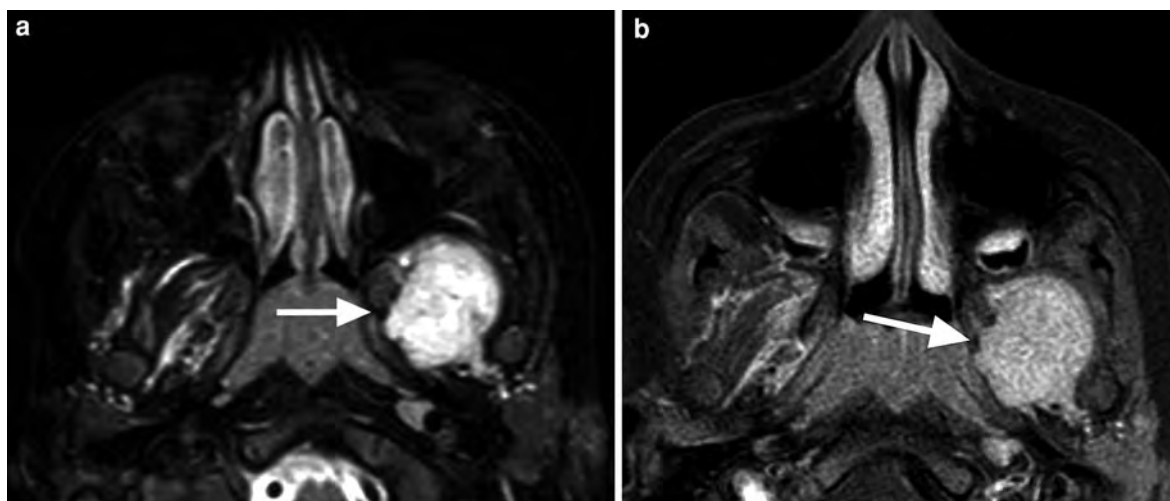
Malignant intrinsic lesion of the left masticator space in a 5-year-old boy presenting with trismus. a Axial T2w fat-suppressed MR image shows a hyperintense mass (*arrow*) in the left masticator space within the lateral pterygoid muscle.
